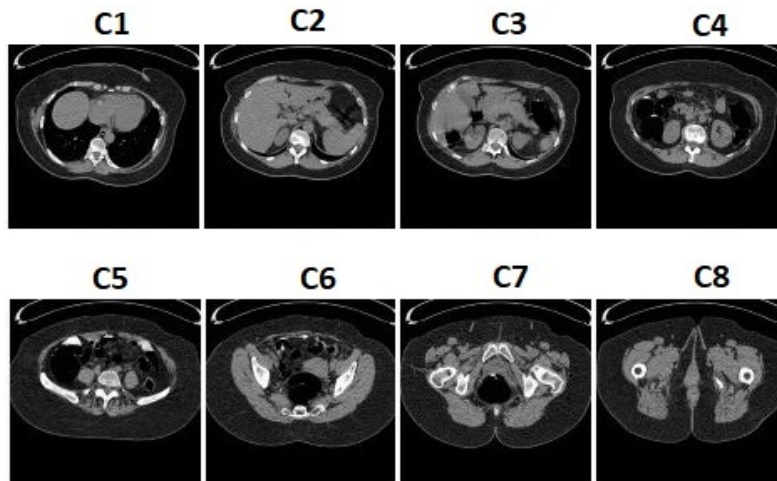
Sample images from each class of TCIA-CT dataset.
